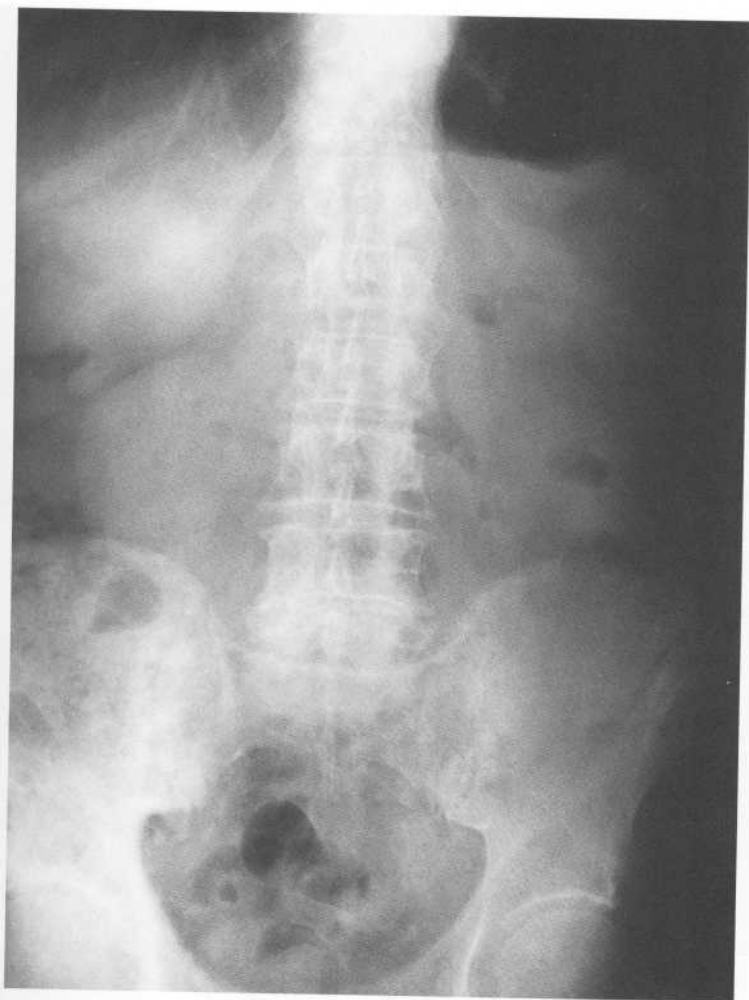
Unilateral sclerosis – right hemipelvis This is a 62-year-old male patient X-rayed for unexplained abdominal pain. No radiological cause was found on the plain films but endoscopy showed a duodenal ulcer.
